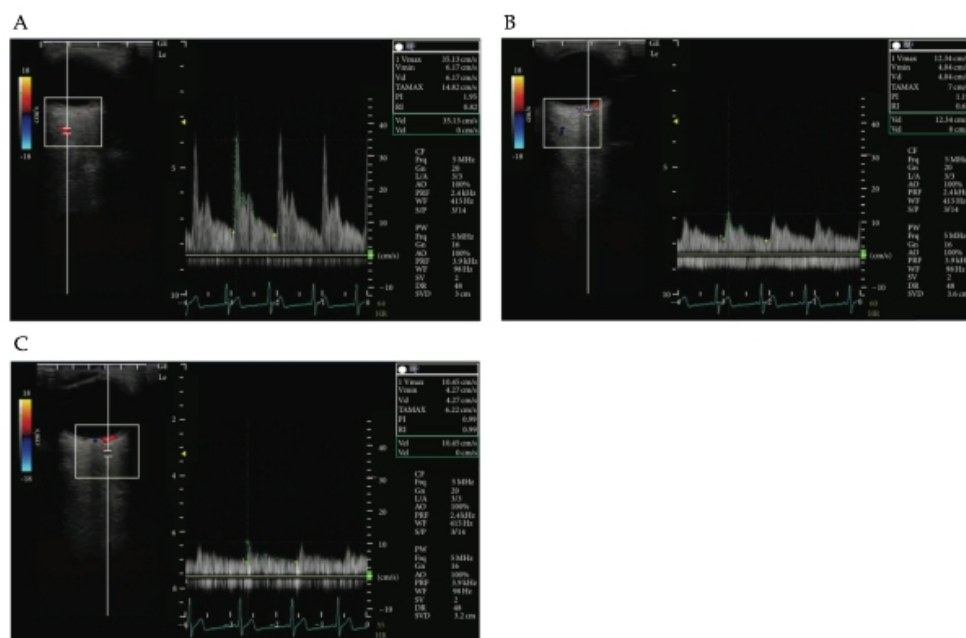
Horizontal scans collected using colour Doppler imaging through the globe showing the (A) ophthalmic artery, (B) central retinal artery, and (C) short posterior ciliary artery.
